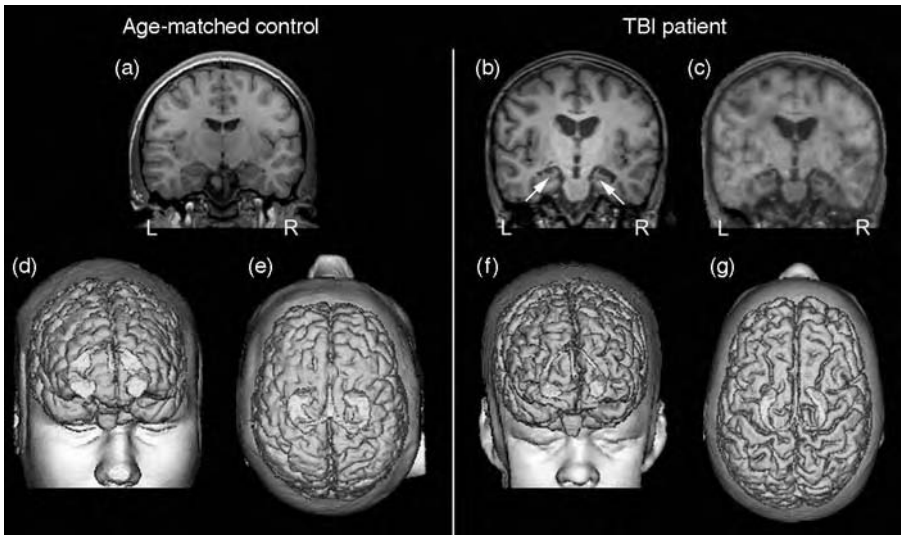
The images on the right are from an 11-year-old who sustained a severe traumatic brain injury (TBI), compounded by an anoxic injury, from a motor vehicle accident. The injury had particular effects on the medial temporal lobe, where positron emission tomography (PET) imaging demonstrated reduced activity. PET imaging has been co-registered with magnetic resonance imaging (MRI), so anatomic detail from MRI can be seen in the background of the superimposed PET scan. In PET imaging, the uptake of a radiotracer determines the level of activity of a particular brain region. In this case, the so-called ‘warm colors’ (orange to red) demonstrate normal activity whereas the ‘cool colors’ (purple to blue) in the medial temporal lobe regions bilaterally depicts less than normal activity. This child also had very significant hippocampal atrophy (arrows in b point to hippocampus – compare to similar level and normal appearance of the hippocampus in a), where quantitatively hippocampal volume was determined to be 35% of normal. In comparison to the age-matched control, this loss in hippocampal volume can be visibly determined as well. Note also, the brain injury resulted in some generalized volume loss with prominence of the lateral ventricles and cortical sulci. (A colour version of this figure is given in the Plate section.)
